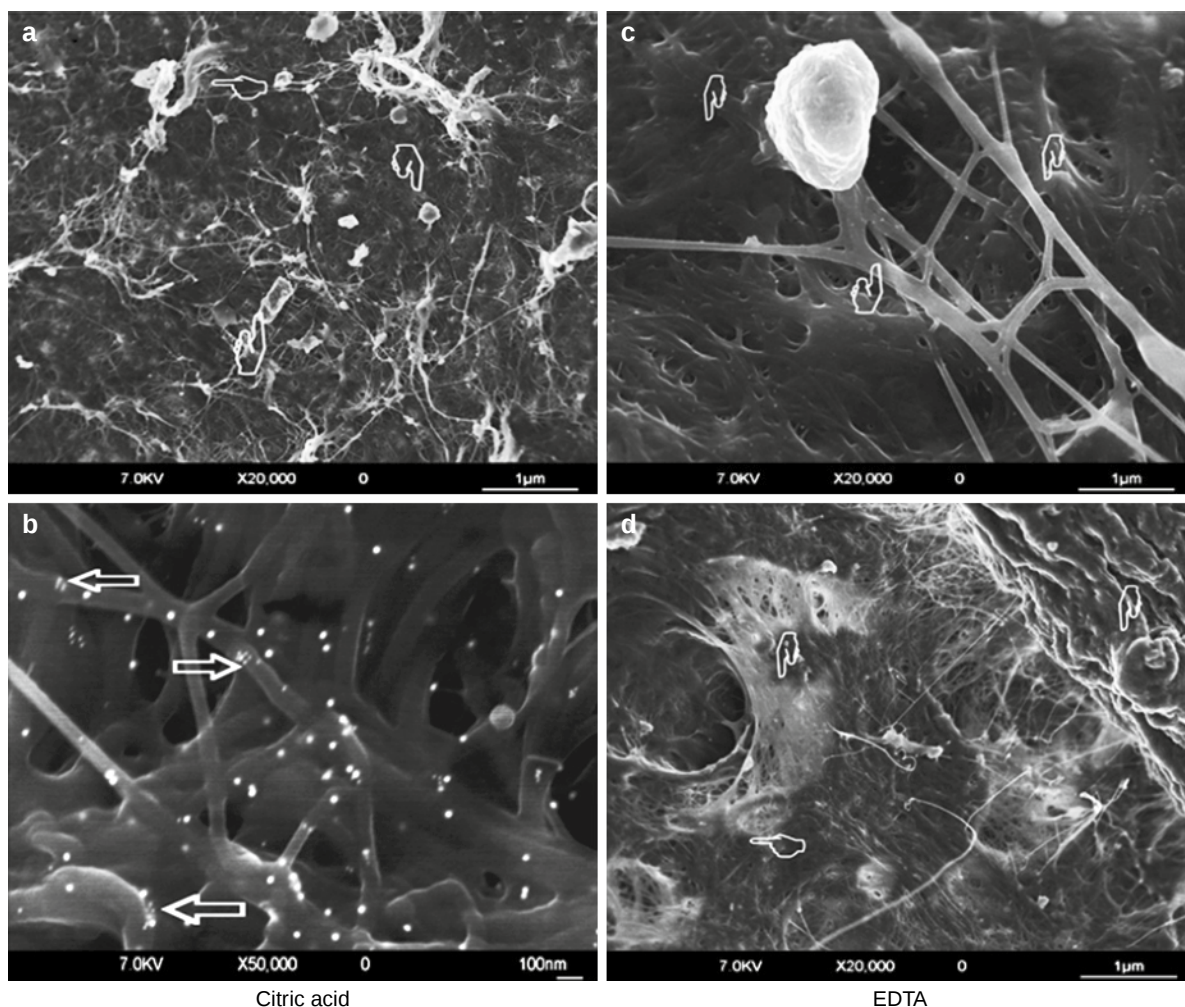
FEISEM images of dentin surface after ultrasonic instrumentation, and either citric acid (Group B1) or EDTA (Group B2) exposure and immunocytochemical labeling of collagen and proteoglycans. (a) Low magnification image reveals residual organic debris scattered on the surface (*pointers*) after citric acid etching (Group B1). (b) Citric acid exposure produces porous intertubular zones revealing the collagen fibrillar network with intense labeling for both collagen and proteoglycans
